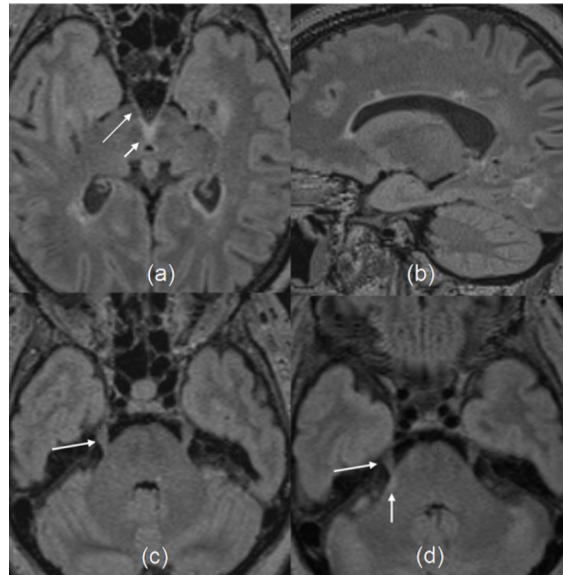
Patient initially presenting with diplopia and internuclear ophthalmoplegia. Initial MRI with modified axial 3D FLAIR reconstruction (a) shows signal abnormality (small white arrow) at the 3rd nerve attachment in upper midbrain. The 3rd nerve is clearly seen in (a) (long white arrow). Sagittal reconstruction (b) shows periventricular white matter lesions characteristic of demyelination. Axial reconstruction (c) through pons at the attachment of trigeminal nerve (white marrow) shows no signal abnormality. Patient subsequently presented with pain right side of face. Follow up MRI with 3D FLAIR (d) shows signal abnormality at the attachment of right trigeminal nerve (small arrow in d)
